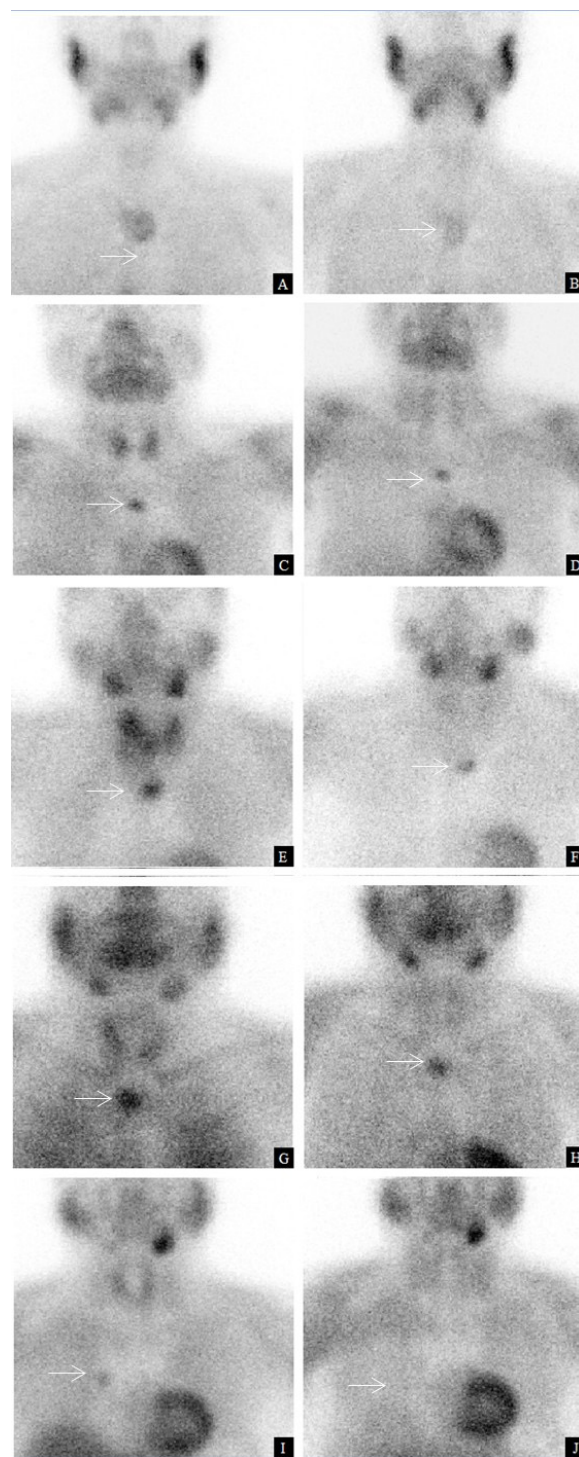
Dual-phase 99mTc-sestamibi (MIBI) planar parathyroid scintigraphy (Cases 1–5). Early-phase images are shown in (A,C,E,G,I), and delayed-phase images in (B,D,F,H,J). Cases are arranged from bottom to top (Case 1 to Case 5). Arrows indicate the focal area of increased radiotracer uptake, with persistent uptake on delayed images, supporting hyperfunctioning parathyroid tissue in the appropriate clinical context.
